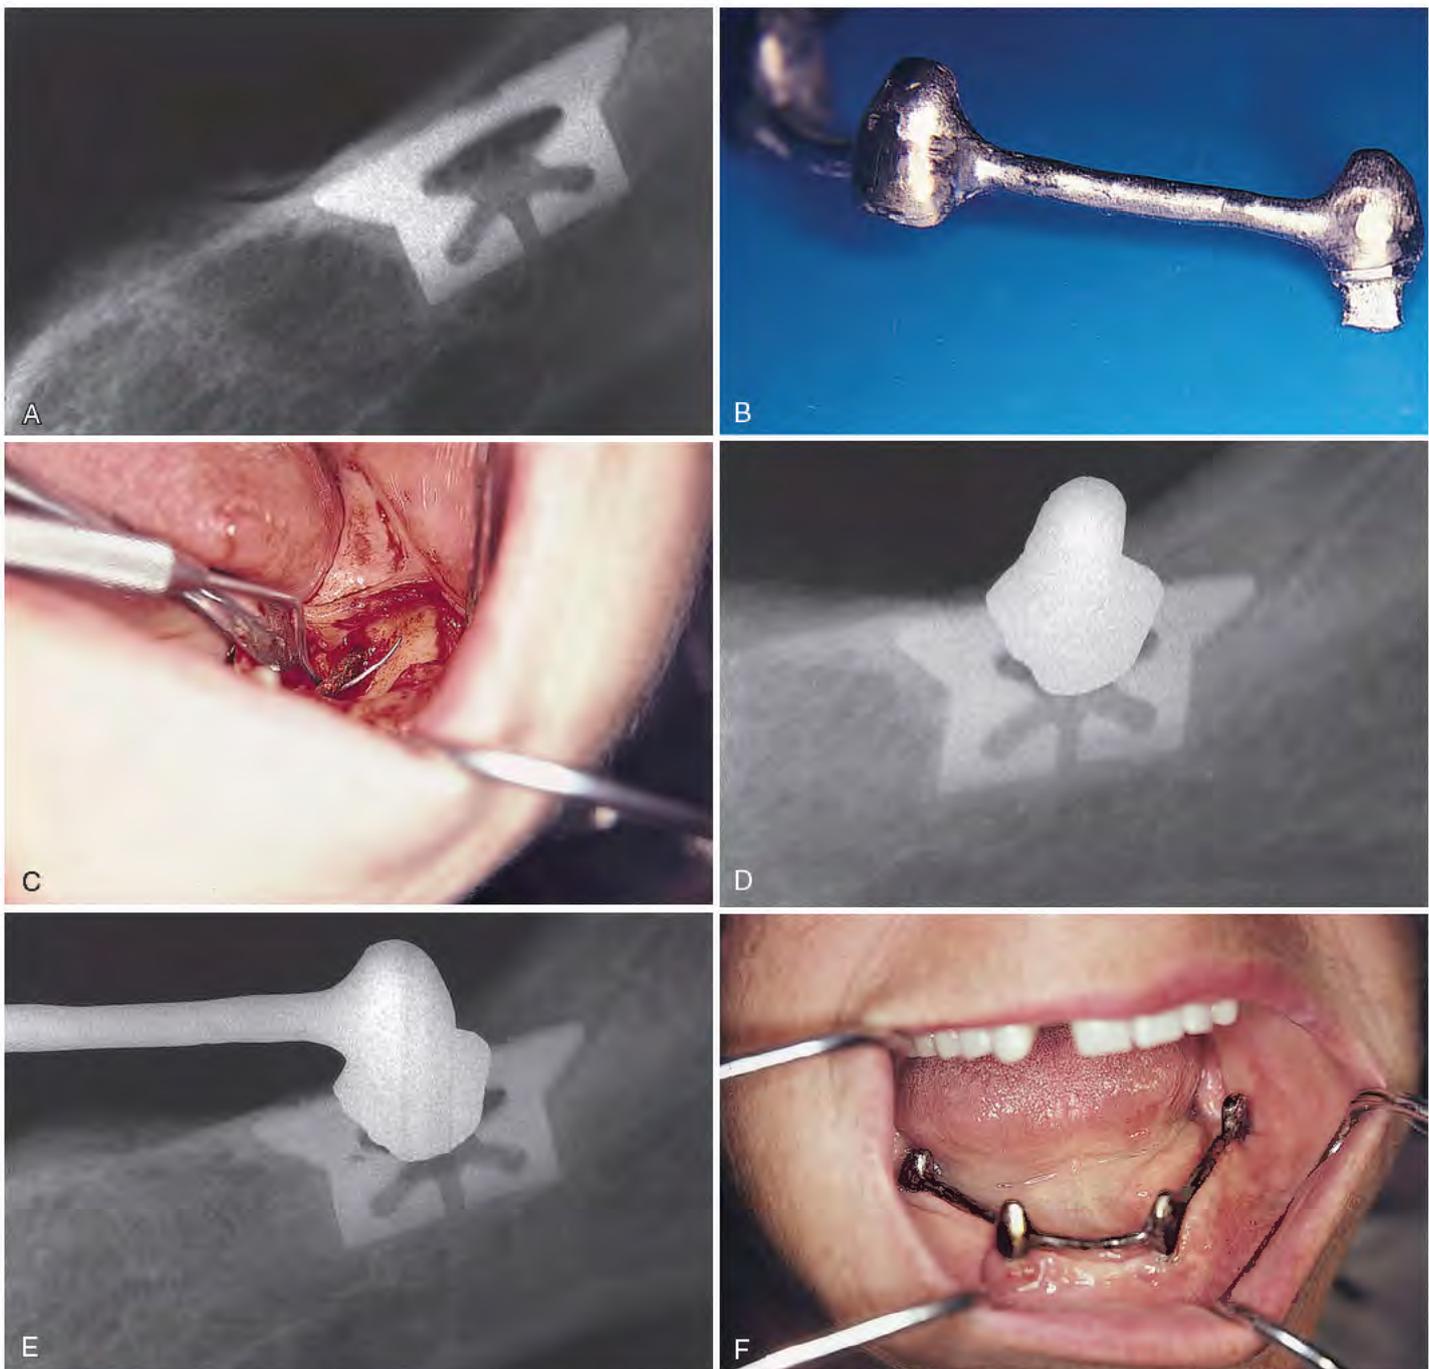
A, A 16-year-old blade implant fractured at the cervix. B, It had served as the distal abutment for a coping bar–overdenture reconstruction. The bar and fractured abutment are shown here. C, The shoulder of the integrated blade had to be exteriorized. After this was done, an explorer could be passed beneath it. D, The new abutment, consisting of twin, separately cast leaves, was affixed with SMS screws. This radiograph shows the reconstruction. E and F, Six-year postoperative radiograph and photograph of the repaired implant with a functioning bar and overdenture.
